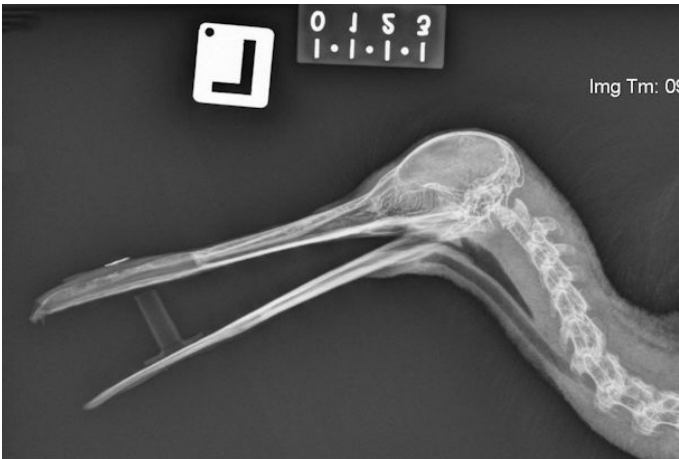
Lateral radiograph advanced osteomyelitis secondary to a crush injury of the bill 12 months previous.
